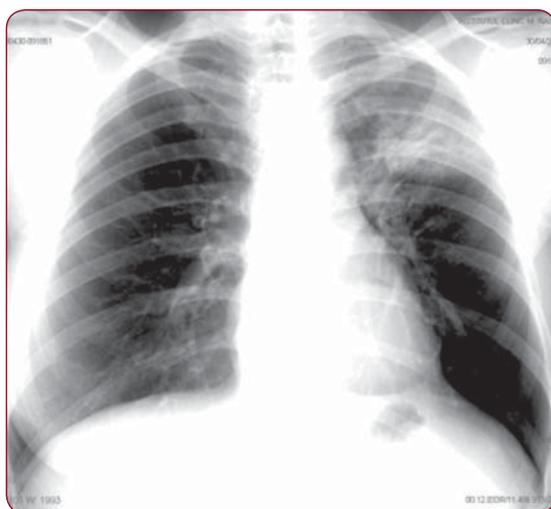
Chest radiography with left upper lobe infiltrate
